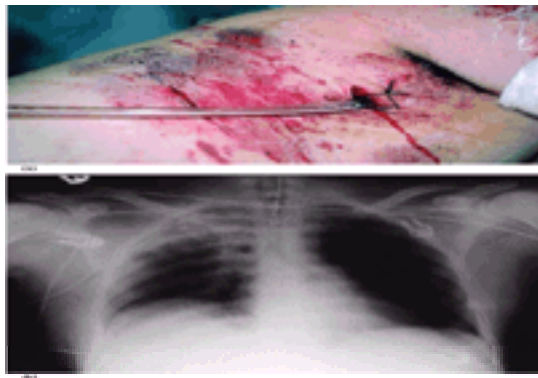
(a) Chest drain inserted at the level of the axillary fold in a patient with right chest trauma. (b) Plain chest radiograph showing a well-sited drain at the right apex with complete evacuation of the haemopneumothorax.
